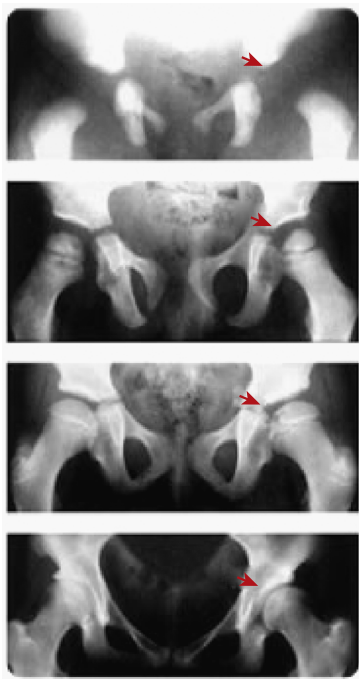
Hip Dysplasia in Children. Developmental dysplasia of the hip (DDH) with residual acetabular dysplasia. Radiographs at birth, 3, 10, and 19 years (top to bottom) show persisting dysplasia.
